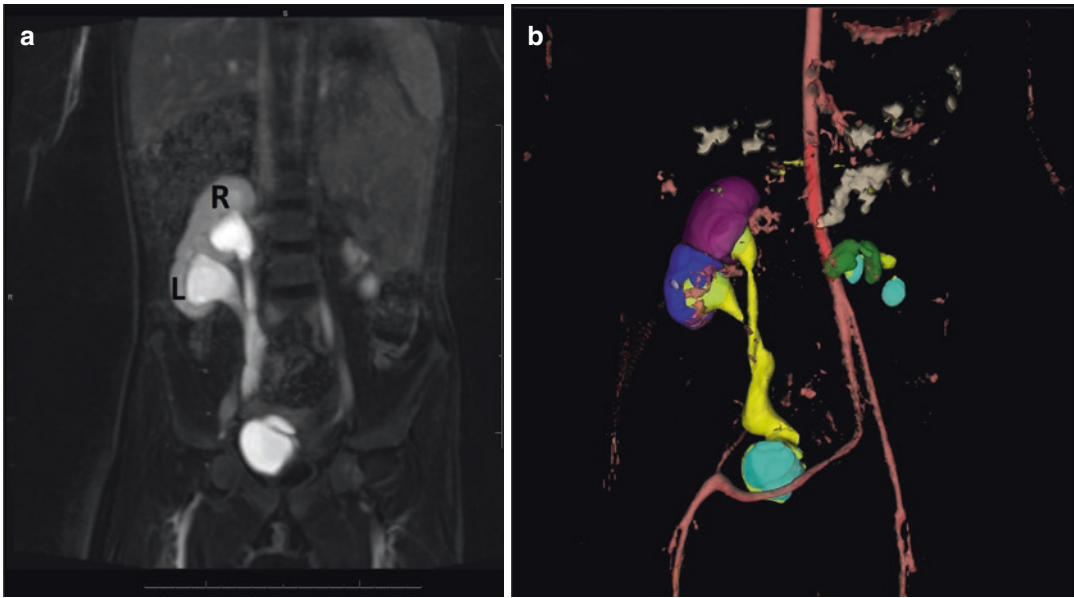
(a) Coronal T2-weighted fat-suppressed MR image of an eight-year-old girl with history of cross fused renal ectopia demonstrates the fusion of the left kidney (L) to the right kidney (R) at the lower pole with respective ureters mildly prominent and coursing inferiorly. (b)
